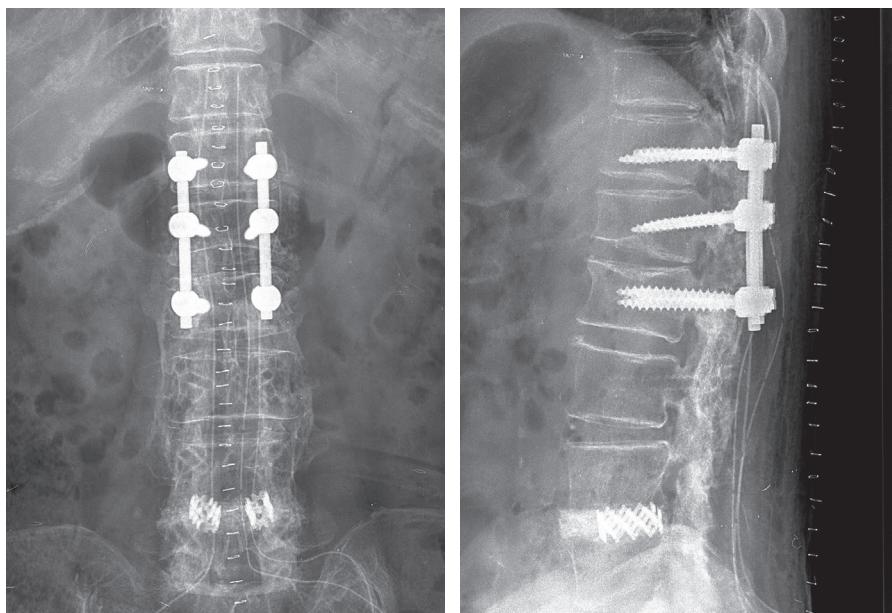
Immediate postoperative plain radiographs after posterior decompression and fusion at T12–L2: (Left) anteroposterior; (Right) lateral. Previous inserted fusion instrumentation was removed.
